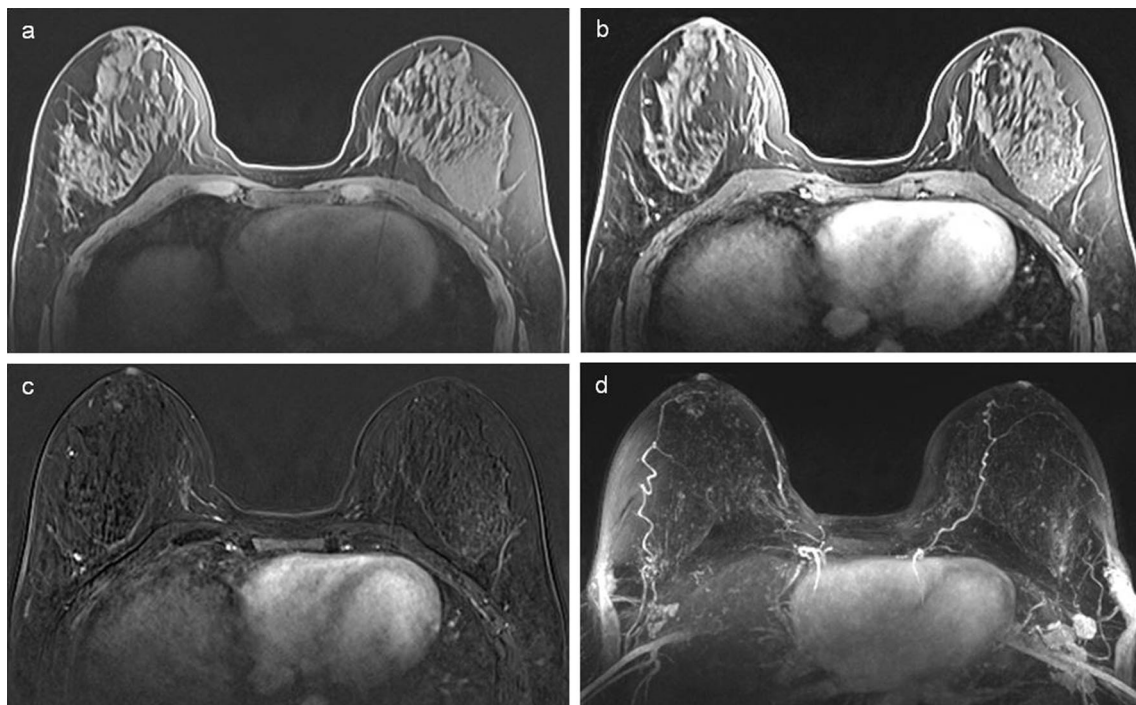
a Axial unenhanced T1-weighted fat-suppressed, b axial contrast-enhanced T1-weighted fat-suppressed, c axial contrast-enhanced T1-weighted fat-suppressed subtraction, and d axial
